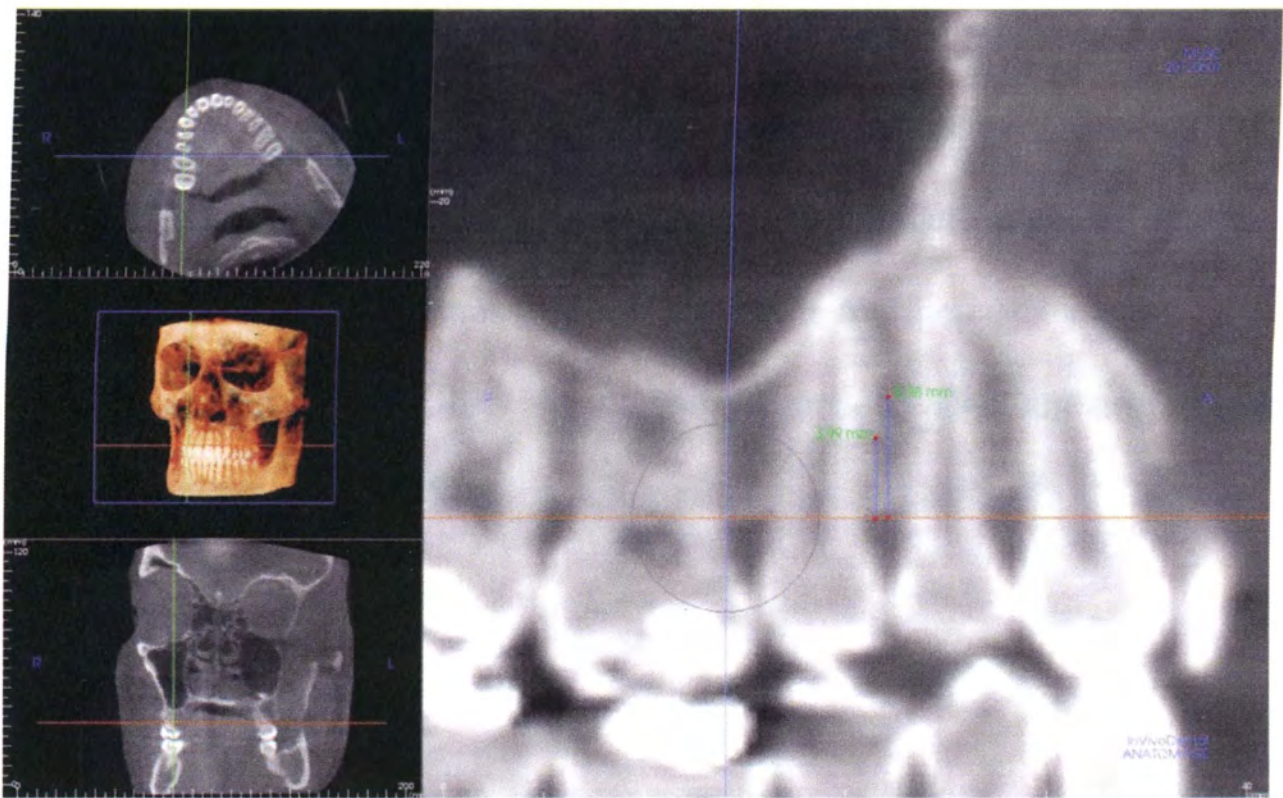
CBCT orientation for vertical level measurement. This is the view utilized in step 4 of the orientation process for each CBCT evaluated marking levels 4 and 6mm from the alveolar crest.
